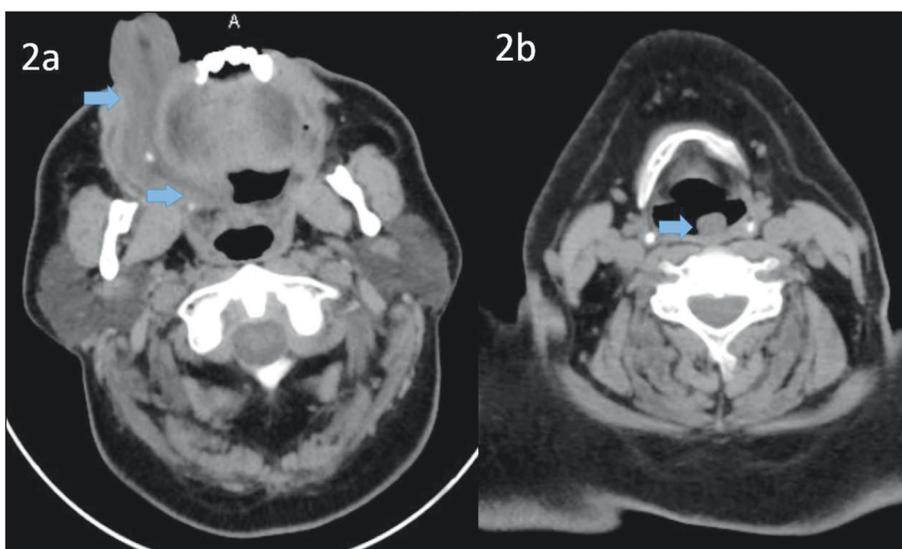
a) Giant fibrovascular polyp was shown with a blue arrow in the oral section of the computed tomography scan. b) The origin of giant fibrovascular polyp was shown with a blue arrow in the hypopharynx section of computed tomography scan.
